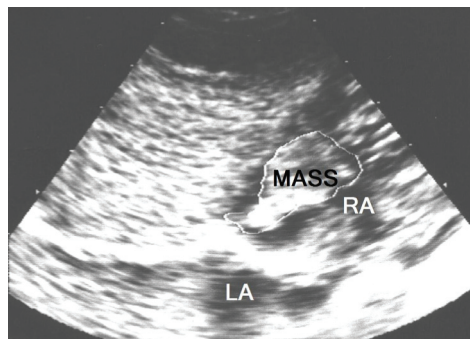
Transthoracic Echocardiography shows the right atrial mass.
